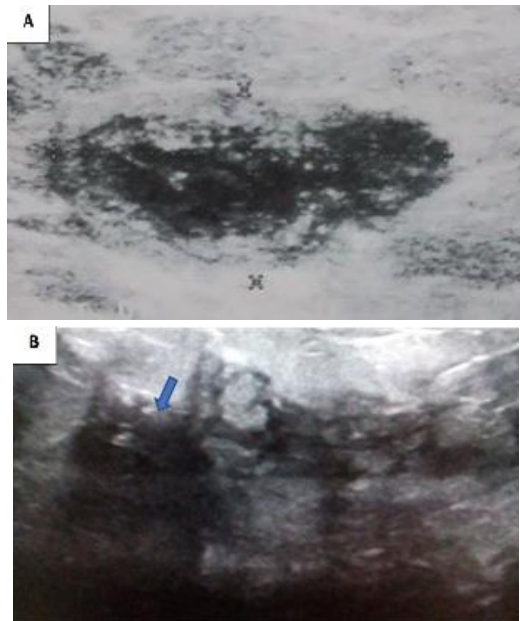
Ultrasound image showing a well (A) or poorly defined (B) mass (arrow)
